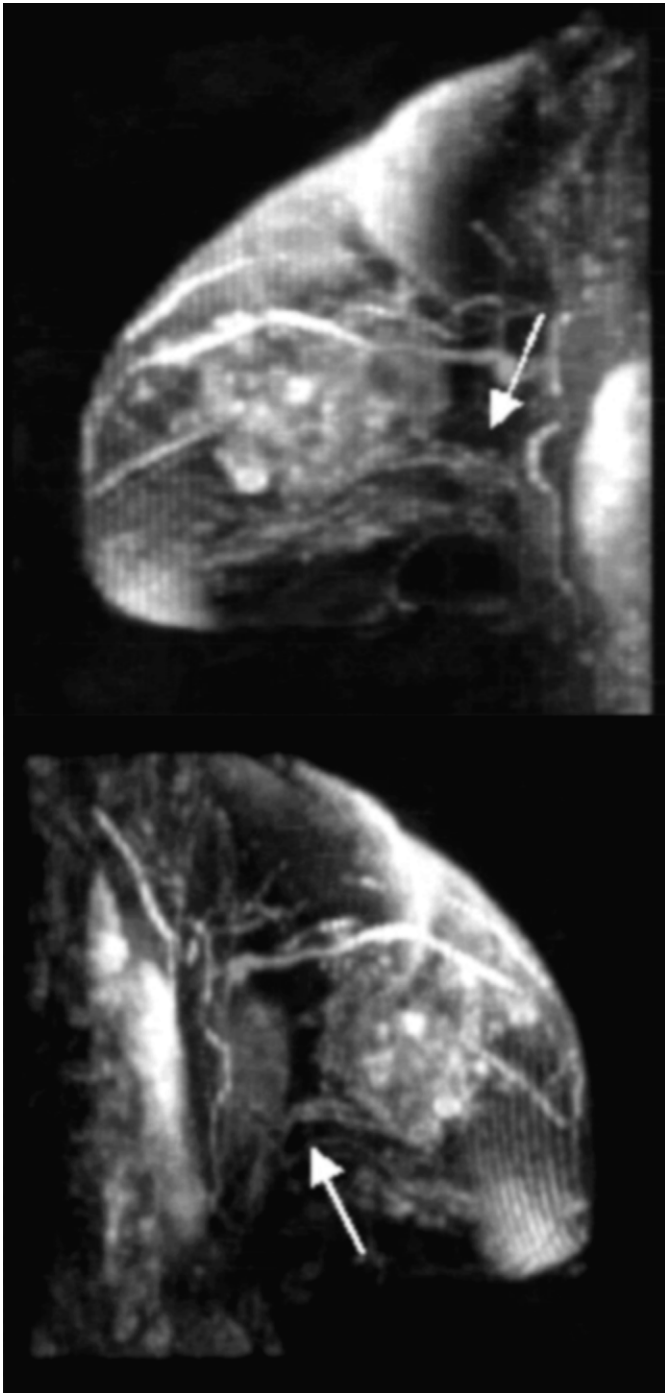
MRI (lateral and oblique MIP reconstruction): note the linear enhancement in the inferior-posterior region of the mass.
